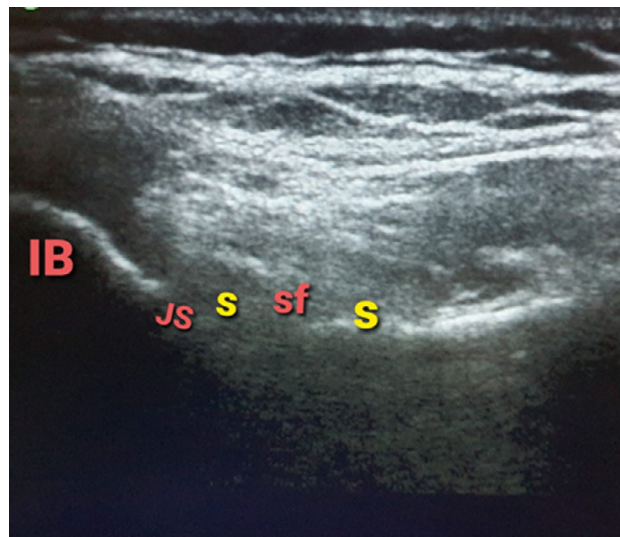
Ultrasound-guided sacroiliac joint injection. IB, iliac bone; JS, joint space; S, sacrum; sf, second sacral foramen. (Courtesy of Kasr Al-Ainy Hospital, Cairo University 2020.)
